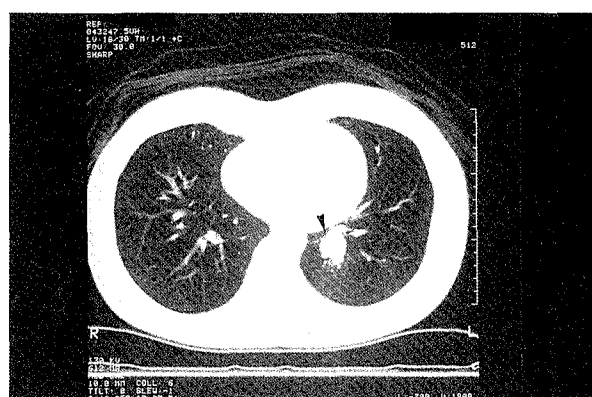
Thoracic computed tomograph reveals a well-defined nodule (arrowhead), measuring 2 x 2 cm in size, without calcification and fat content, located in the left lower lobe.
